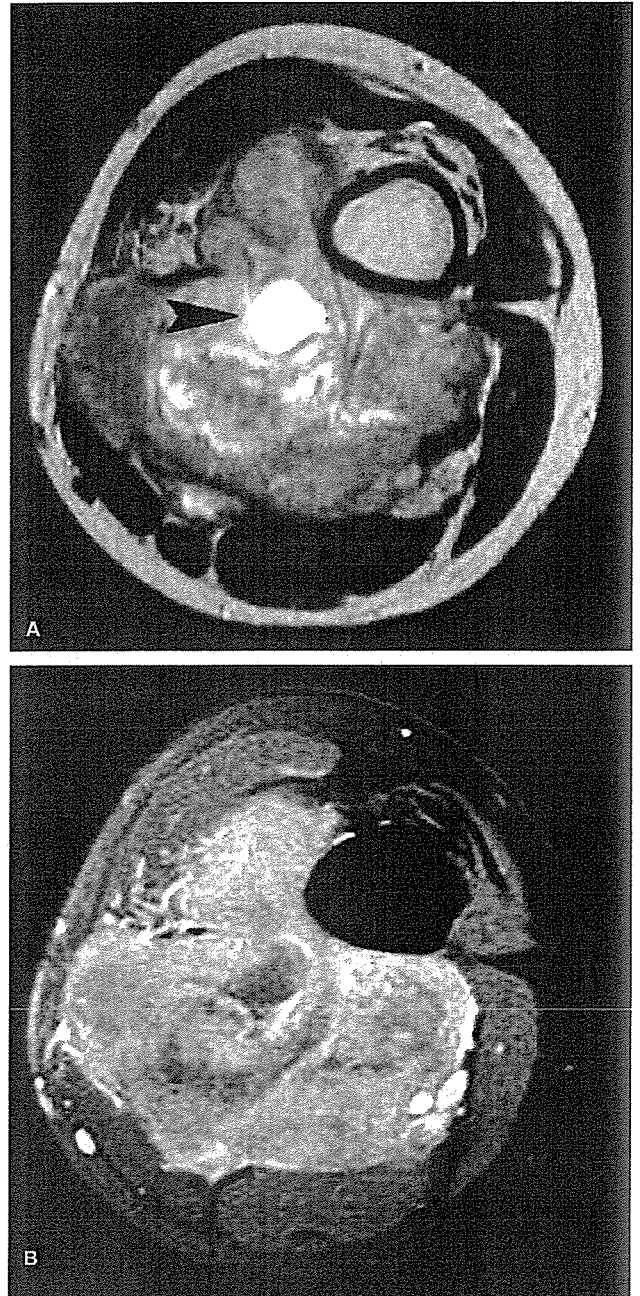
A 17-year-old man with synovial sarcoma (high-grade) in left thigh. A, Axial T2-weighted fast spin-echo (3500/100) MR image at the level of femur shows a large irregular mass of heterogeneous signal intensity. Also noted is central cystic degeneration (arrowhead). B, Fat-suppressed contrast-enhanced T1-weighted spin-echo (650/12) MR image demonstrates heterogeneous enhancement.
